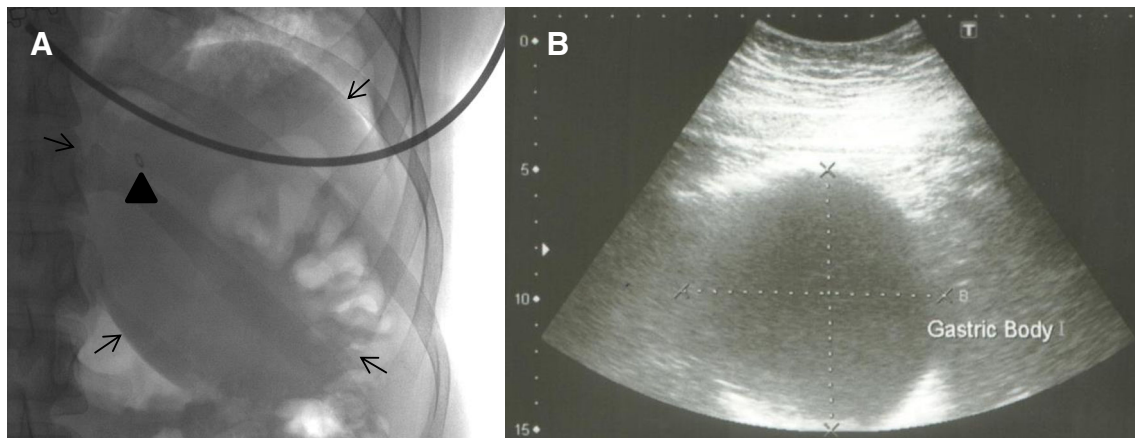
X-ray (a) and ultrasound (b) of Elipse™ after it is filled. The outline of the Elipse™ balloon (arrows) and the radiopaque marker inside the balloon (arrowhead) can be seen on x-ray (a) and the outline of the balloon can be seen on ultrasound (b)
